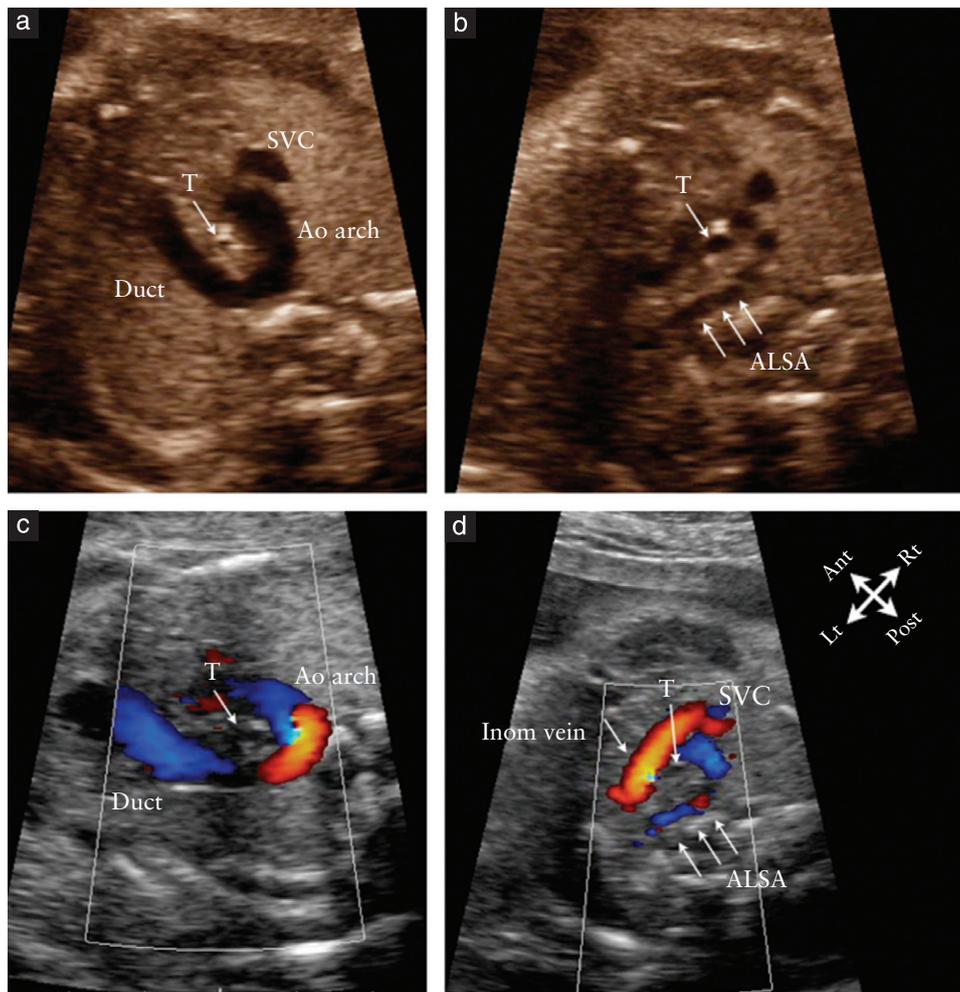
B-mode (a,b) and color Doppler (c,d) ultrasound images of upper mediastinum in Case 22 at 28 weeks of gestation. Note the right-sided aortic arch, left-sided arterial duct and aberrant origin of left subclavian artery (ALSA) coursing behind the trachea (T). Ao arch, aortic arch; Inom vein, innominate vein; SVC, superior vena cava.
